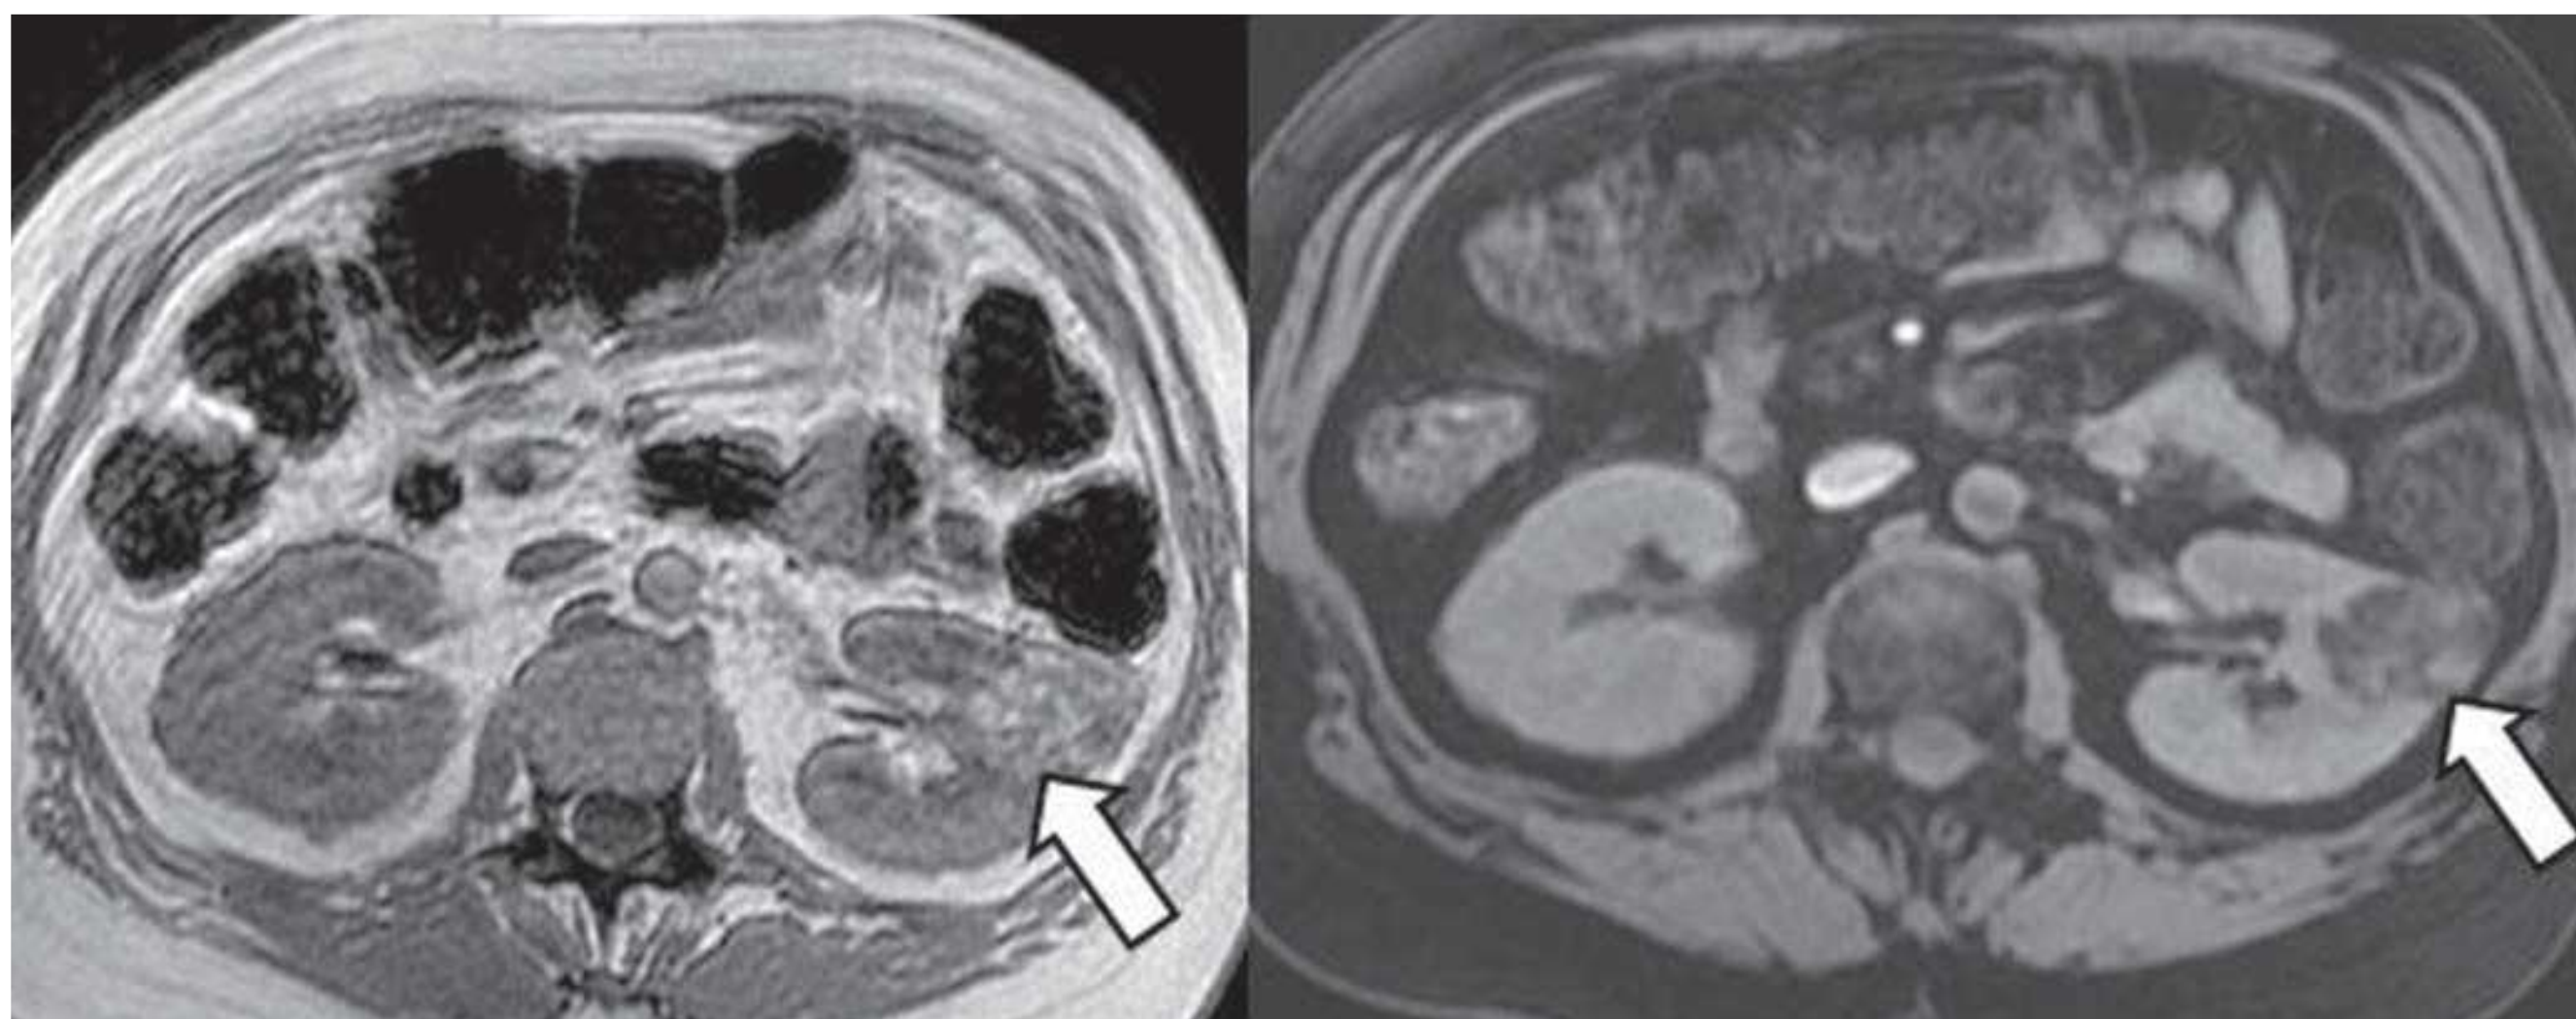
Angiomyolipoma (*arrow*) in the left kidney with bright signal intensity similar to the surrounding body fat on T1-weighted MRI without fat saturation (*left*) but showing a signal drop on T1-weighted with fat saturation (*right*).
